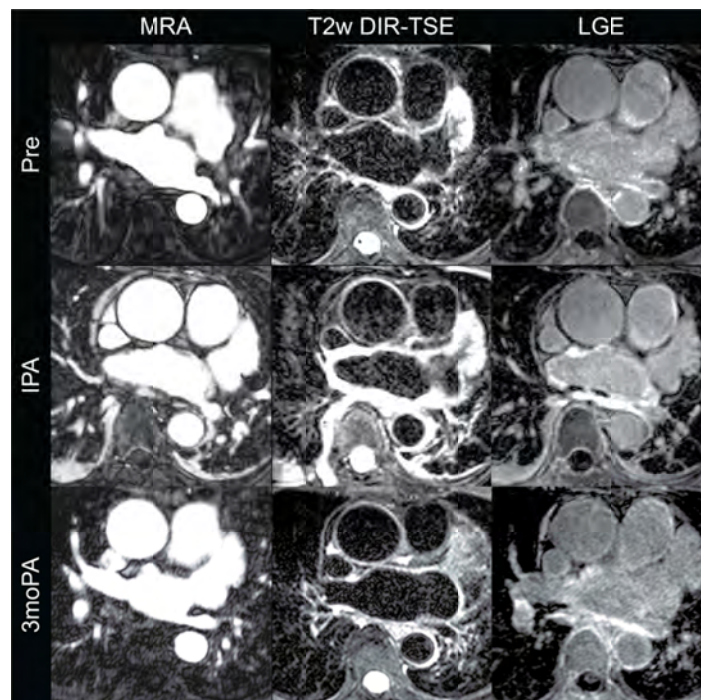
Example of left inferior PV stenosis in a patient who underwent radiofrequency ablation for atrial fibrillation. Pulmonary veins were assessed on serial MRI scans (Pre, IPA, 3moPA) using 3 different sequences for tissue characterization. PV stenosis is best assessed by MRA. Development and resolution of edema/inflammation surrounding the veins are seen on T2w DIR-TSE, and remodeling changes resulting in scar are seen on LGE.
